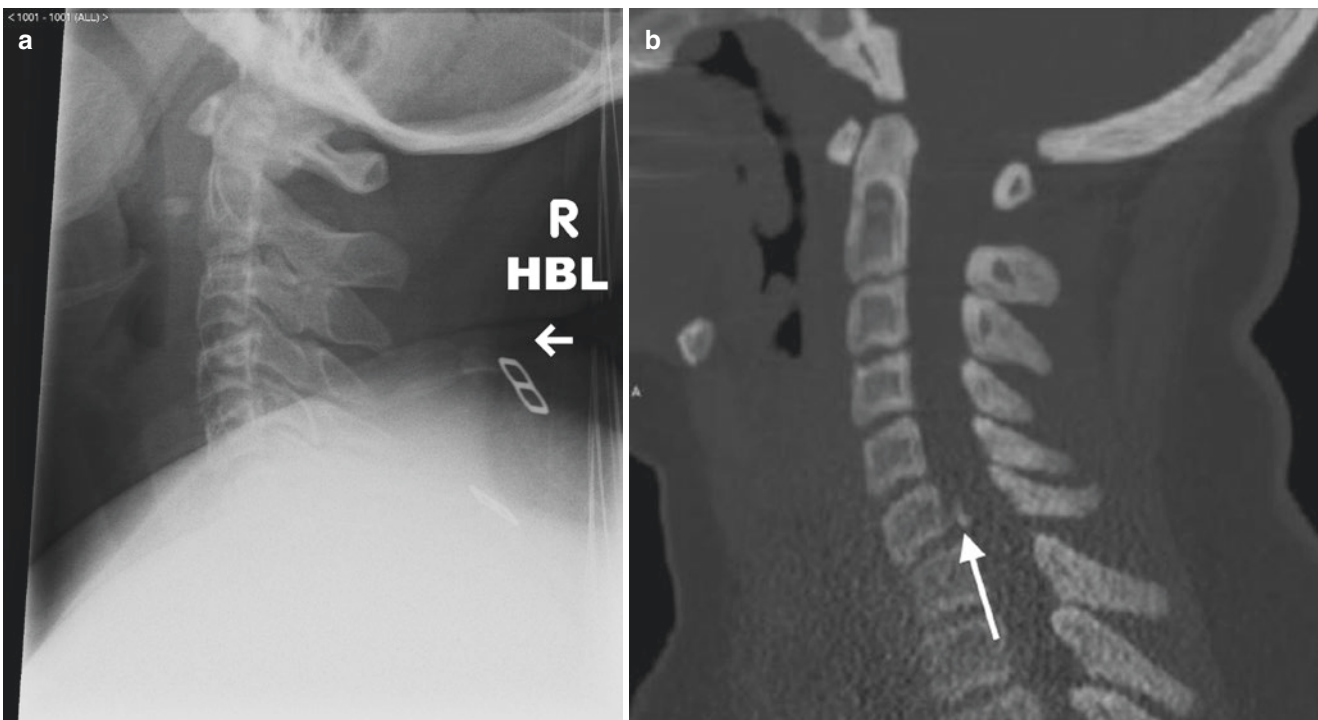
(a) Inadequate lateral cervical spine radiograph, in which the cervical spine is visualised only down to the C5 vertebra. (b) Sagittal reformatted CT image in the same patient reveals a fracture
